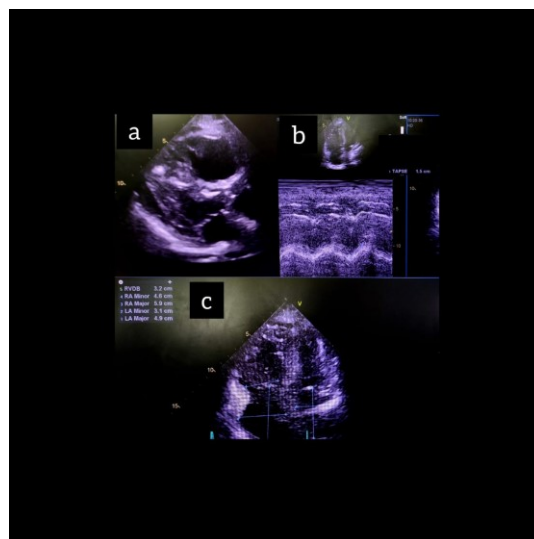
Echocardiography showing an enlarged right ventricle, Parasternal long axis view. B. Decreased tricuspid annular plane systolic excursion (TAPSE 1.5cm). c. Dilated RV and McConnell sign (arrow), Four chamber view
